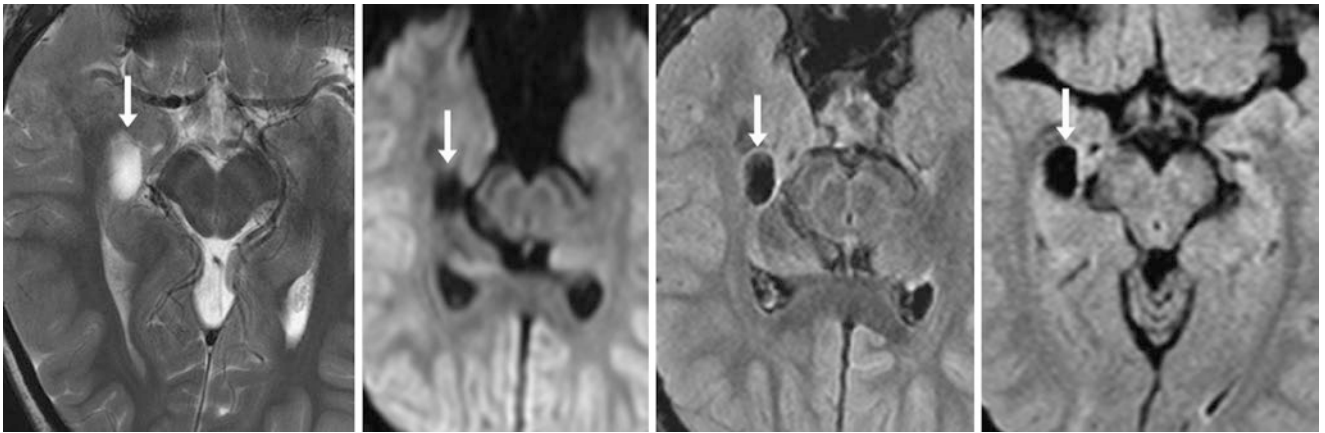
A 6-year-old patient with a well-defined 1.5 cm right CFC (arrows) on a 3 T MRI with axial T2WI (left), having a CSF-like signal on DWI (left middle) and FLAIR (right middle). There was no change
